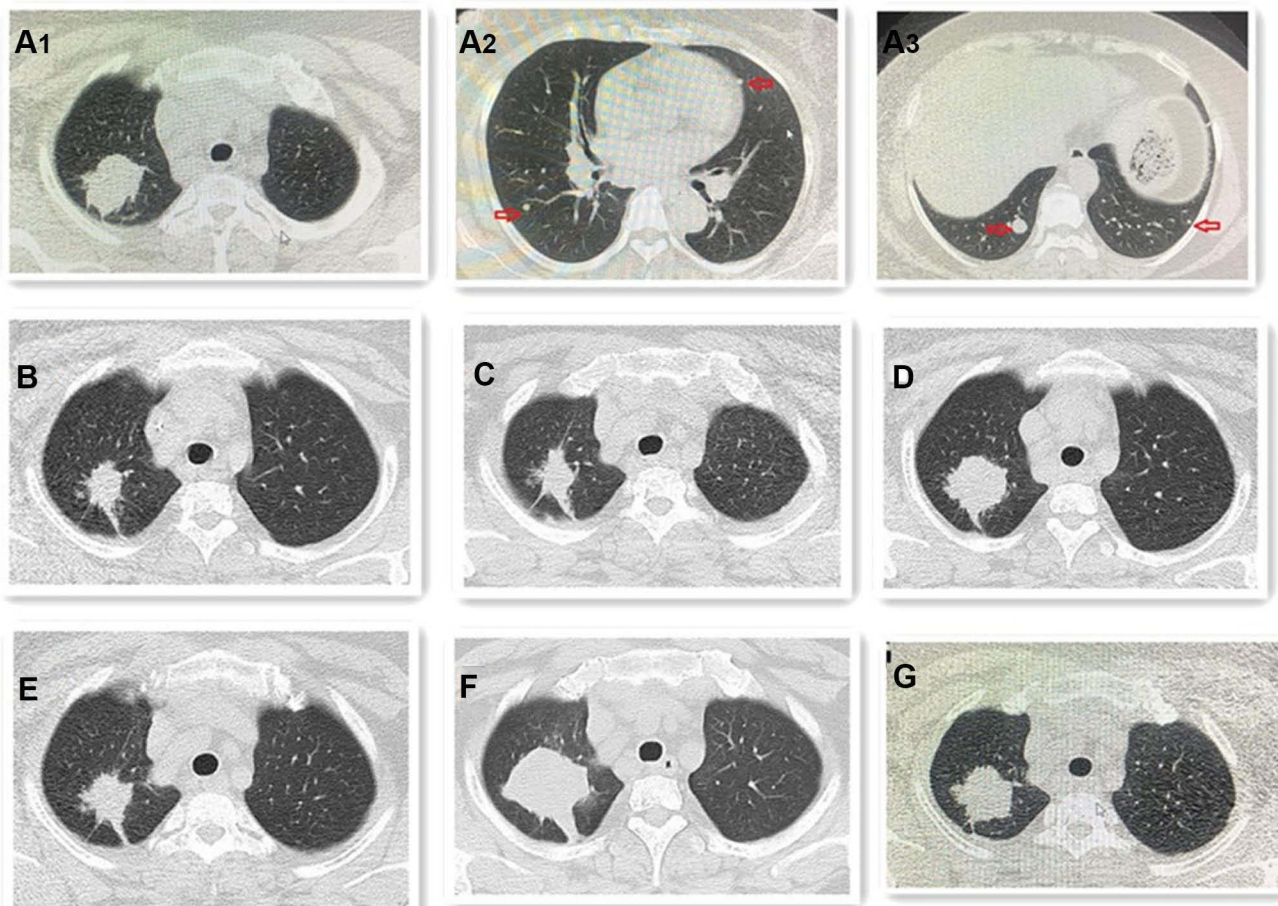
The chest CT outcomes during the whole treatment. (A) (A1–A3) Chest CT reveals primary lung cancer and metastases (red arrow); (B) tumor was PR after 2 cycles chemotherapy and gefitinib; (C) tumor was SD after 2 cycles chemotherapy and gefitinib again; (D) tumor was PD for taking gefitinib only; (E) tumor was PR again after 4 cycles the same chemotherapy and osimertinib; (F) tumor was PD again for taking osimertinib only. (G) Tumor was PR again after 2 cycles anlotinib.
